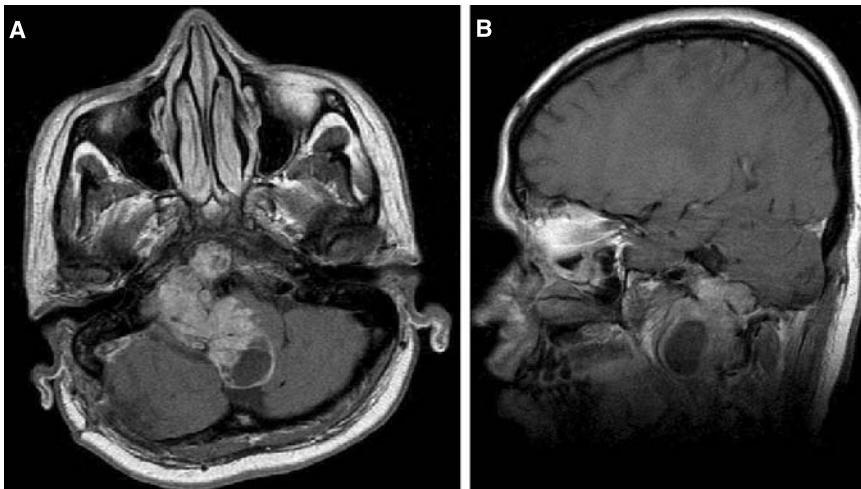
Pre-operative MRI (T1W with Gadolinium) with intracranial and extracranial tumour extent. (A) Axial, (B) sagittal
